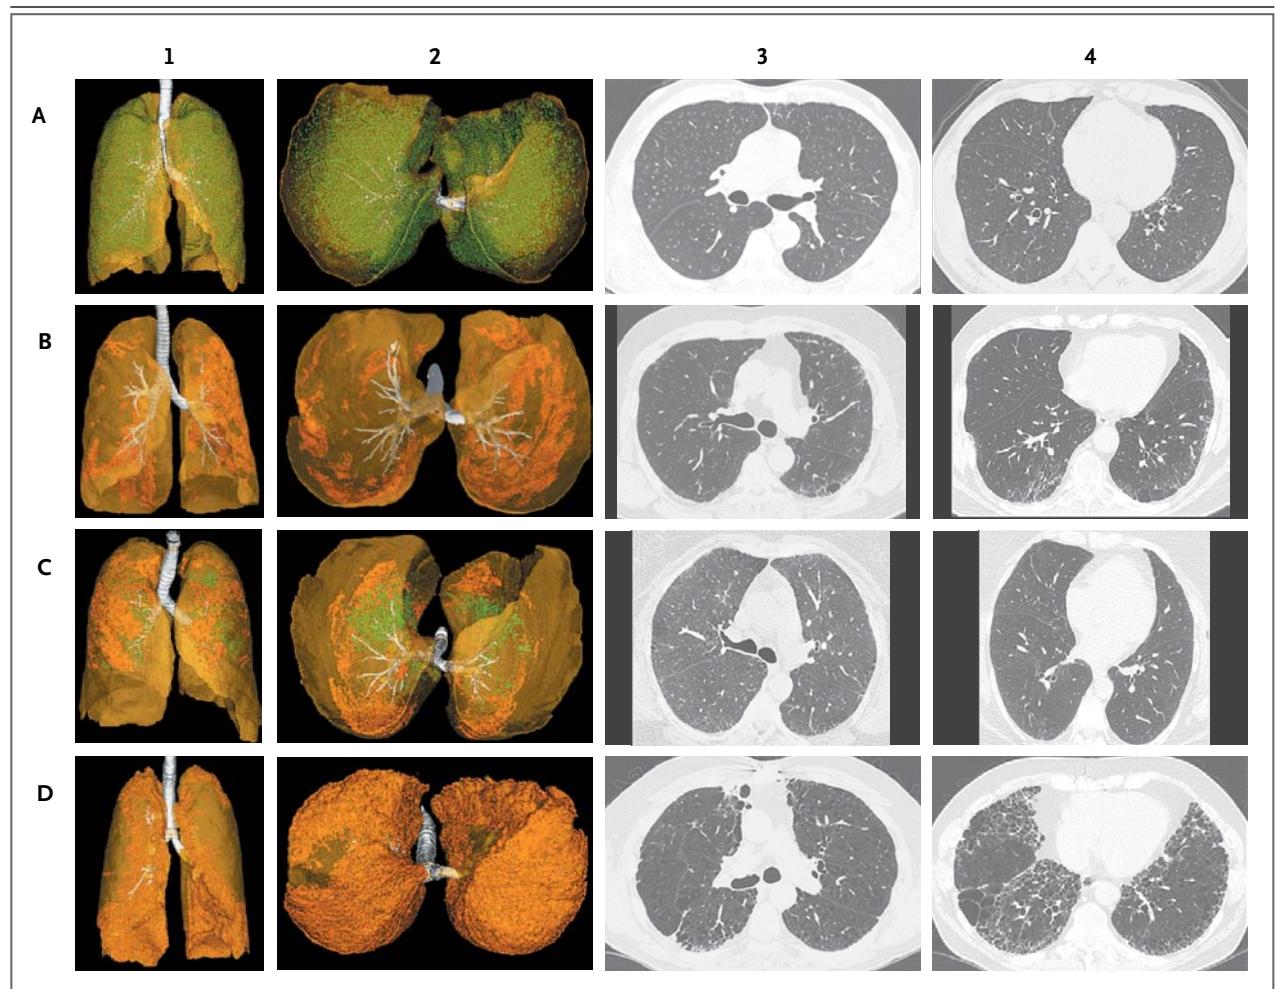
Four Major Radiographic Subtypes of Interstitial Lung Abnormalities.
